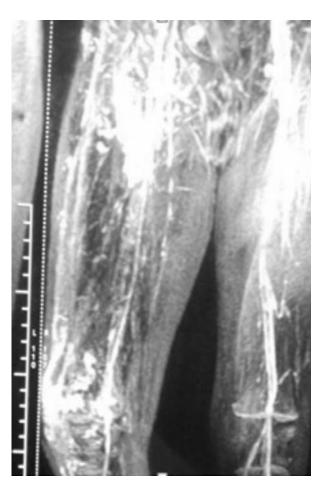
MRI* showing hypertrophy of the right lower limb with underlying AV malformation (dilated vessels infiltrating the subcutaneous fat,muscles, patella and knee joint).
